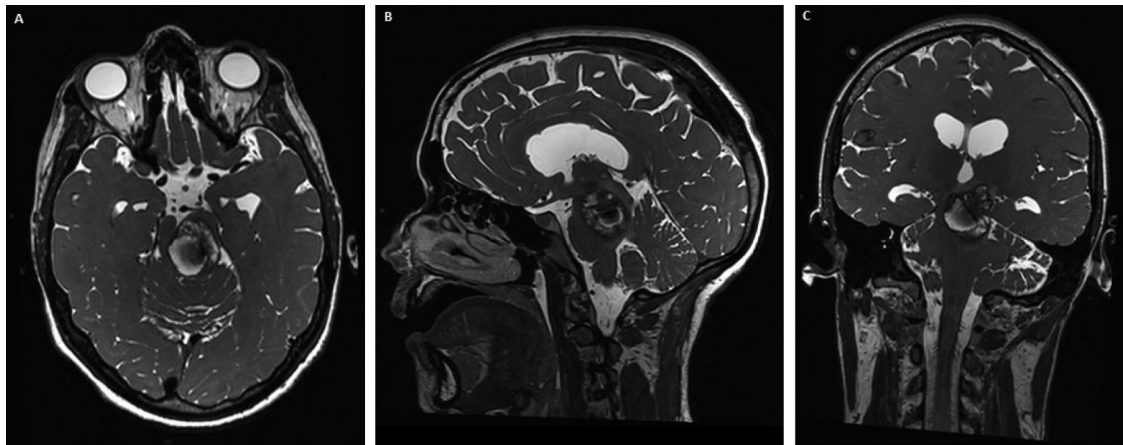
Patient 16: A. preoperative axial; B. Sagittal and C. Coronal T2-weighted brain MRI showing a $2.3 \times 3 \times 3$ cm left mesencephalic cavernoma with extension in the pons.
